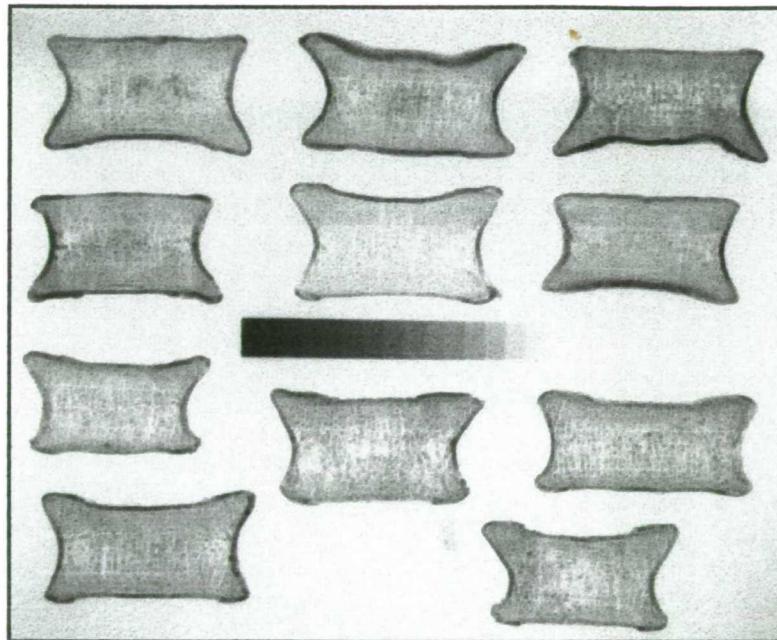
Positive X-ray images of the 4th lumbar vertebral body bone slices with small step wedge.
